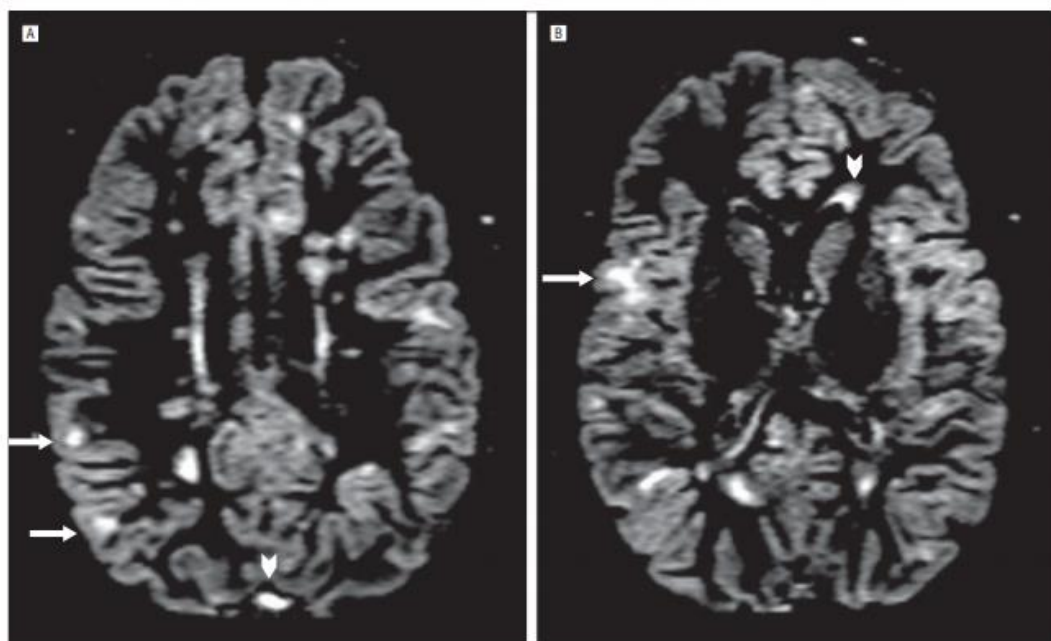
MRI detection of cortical lesions from 2 MS patients. (A) and (B) report MRI on cortical lesions (arrows) in two RRMS patients. Arrowheads indicate artifacts in (A) and CSF effusion in the periventricular white matter in (B) (Calabrese M et al., 2009).
